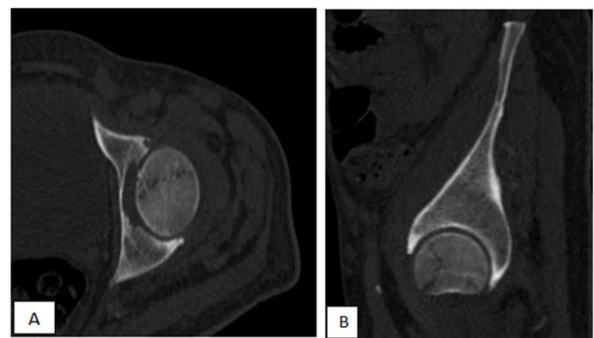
Axial (A) and Coronal (B), CT scan reconstructions, bone window: Geographic osteolytic lesions of left femoral epiphysis related to bone infarcts
